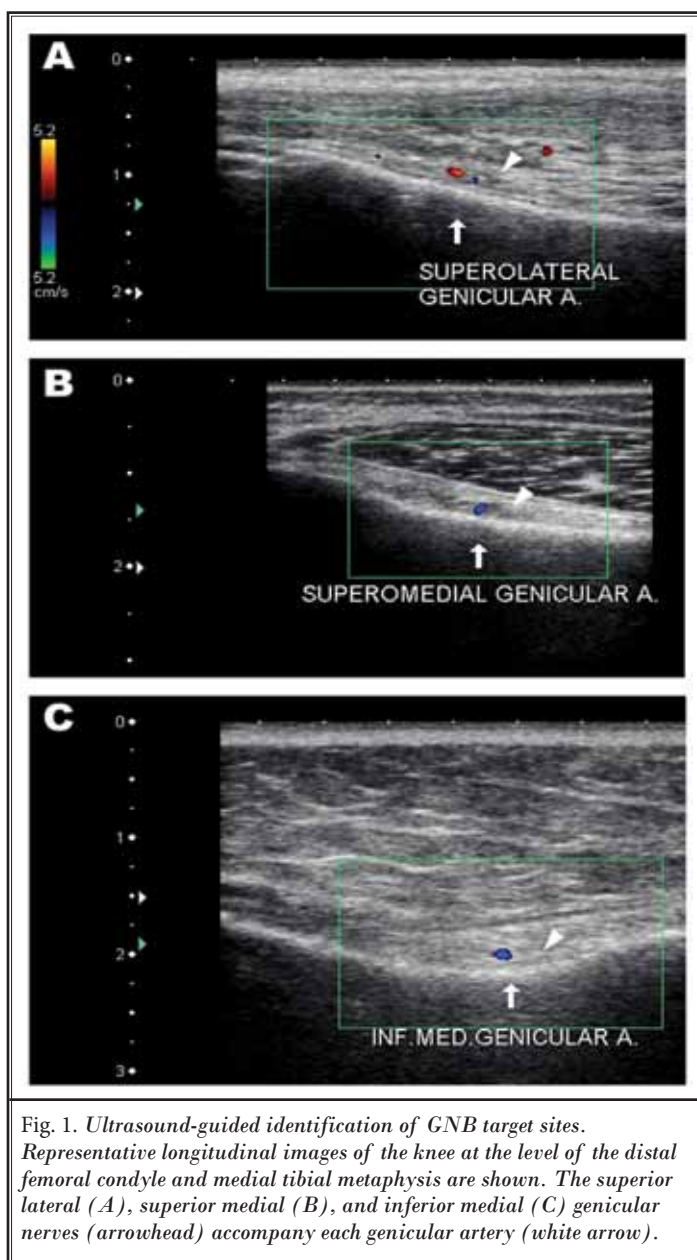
Ultrasound-guided identification of GNB target sites. Representative longitudinal images of the knee at the level of the distal femoral condyle and medial tibial metaphysis are shown. The superior lateral (A), superior medial (B), and inferior medial (C) genicular nerves (arrowhead) accompany each genicular artery (white arrow).
